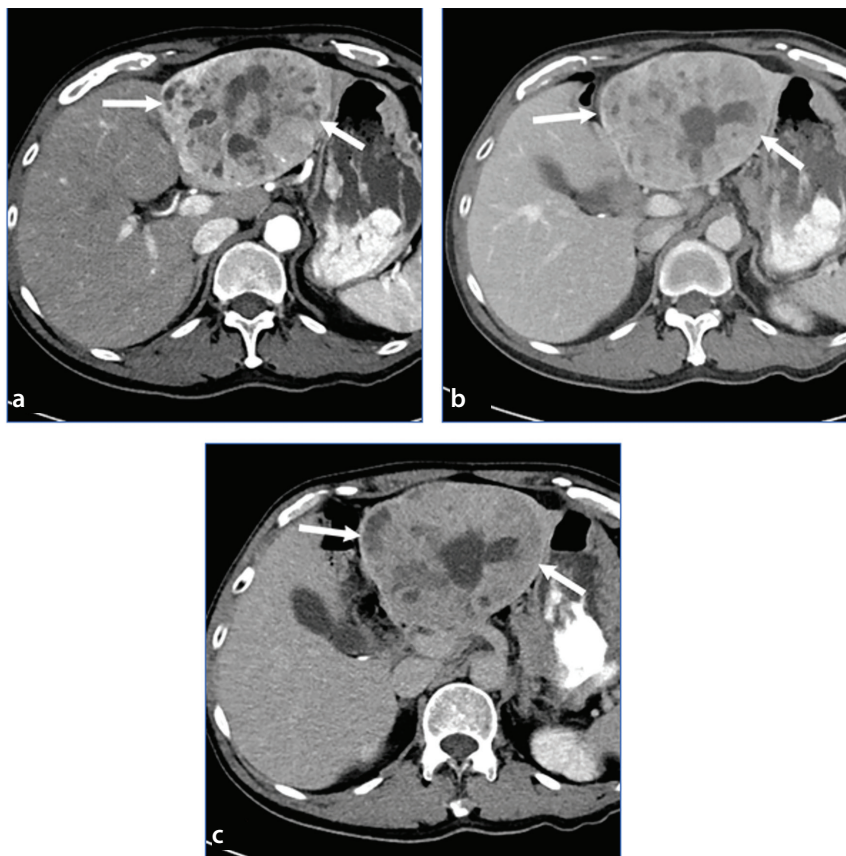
Primary hepatic neuroendocrine tumor. Axial contrast-enhanced computed tomography images of the liver during late arterial (a), portal venous (b), and delayed (c) phases of contrast enhancement show a round, heterogeneously enhancing primary hepatic neuroendocrine tumor replacing the lateral segments of the left lobe of the liver (arrows). The mass demonstrates increased enhancement during the arterial phase (particularly peripherally), washout of contrast material during the portal phase, and increased enhancement on the delayed phase as compared with the surrounding liver parenchyma.
